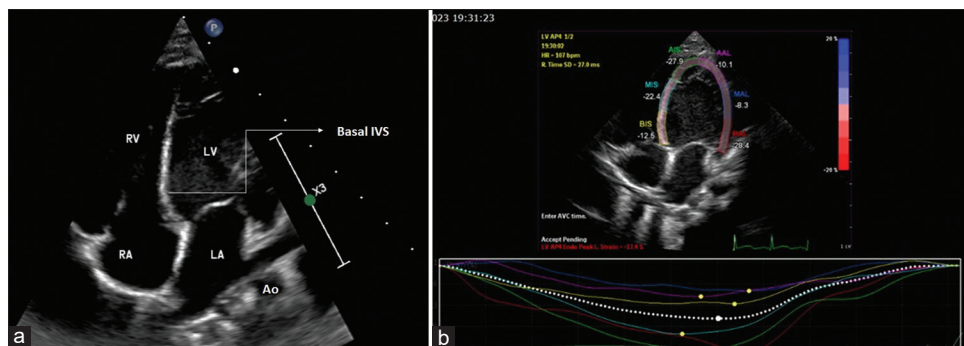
(a) Sixteen-month follow-up echocardiography. Apical four-chamber view showing increased echogenicity of the basal septum with ballooning (arrow), (b) Strain imaging shows borderline global longitudinal strain of -17.4% with localized focal segments of decreased strain rates: Basal inferior septum -12.5, apical anterior lateral segment -10.1, and mid-anterior lateral segment -8.3, IVS: Interventricular septum, LV: Left ventricle, RV: Right ventricle, RA: Right atrium, LA: Left atrium, Ao: Aorta
